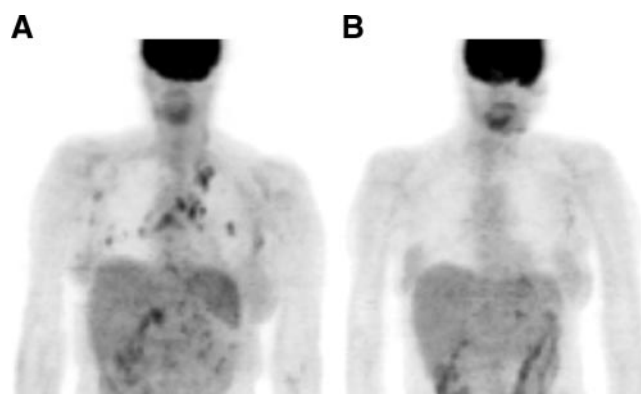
(A) In 45-y-old woman with *S. aureus* septicemia and persistent fever during therapy, PET showed increased ¹⁸F-FDG uptake in multiple lesions in both lungs, mediastinum, and upper abdomen. Subsequently, chest CT also showed multiple lesions in both lungs and mediastinum. Cholangitis caused by gallstones was confirmed by abdominal ultrasound and endoscopic retrograde cholangiopancreatography (ERCP). Fever disappeared within 2 d after ERCP. (B) After 3 mo, ¹⁸F-FDG PET was normal and antibiotic therapy was discontinued.
